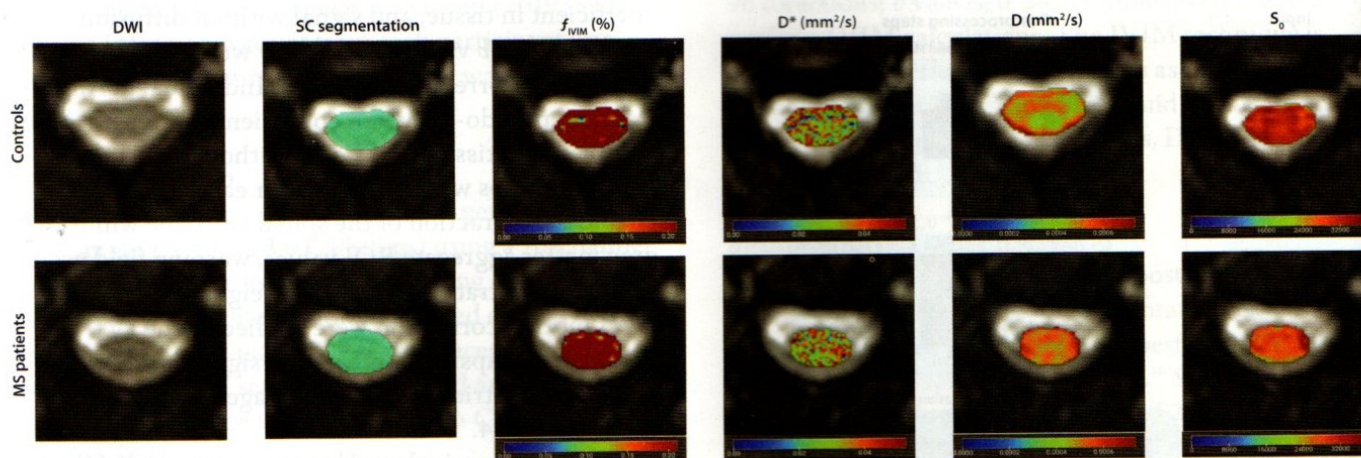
Example of DWI for control participants (top row) and MS patients (bottom row) with SC segmentation and calculation of IVIM metrics (f_{IVIM} , D^* , D , and S_0 [magnetic resonance signal intensity relative to baseline]). Images courtesy of the authors.
